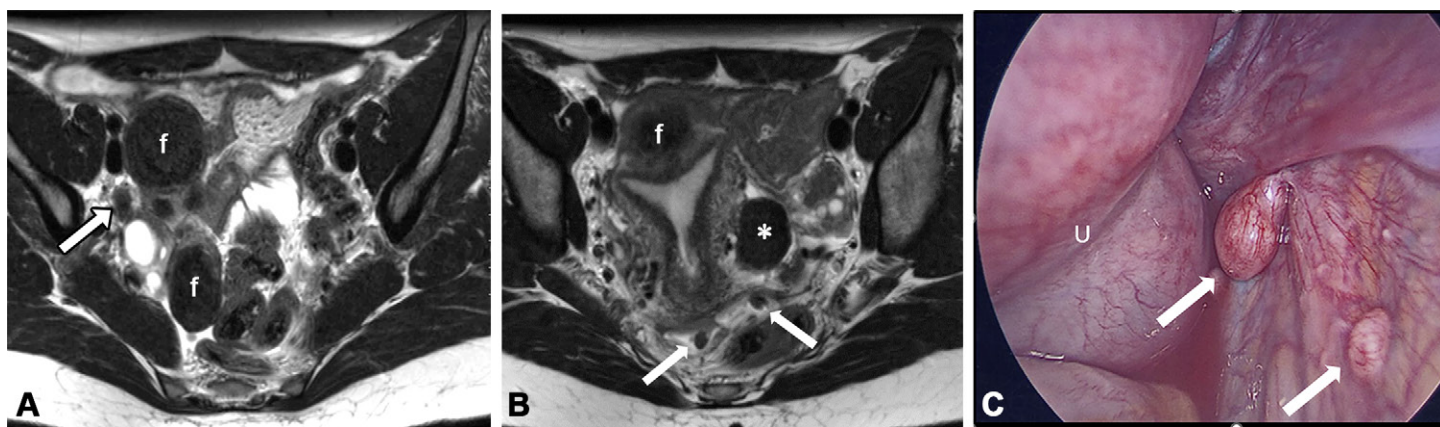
Diffuse peritoneal leiomyomatosis found at workup for infertility in a 40-year-old woman with no prior history of uterine procedures. (A) Axial T2W MR image partially shows multiple subserosal leiomyomas (*f*) and a small hypointense nodule (arrow) along the right pelvic sidewall. (B) Axial T2W MR image at a slightly more inferior level shows a leiomyoma of the left broad ligament (*), additional peritoneal nodules (arrows) in the cul-de-sac, and subserosal leiomyomas (*f*). (C) Laparoscopic image of the right pelvic sidewall shows a fibroid uterus (*U*) medially and multiple nodules (arrows) along the right pelvic sidewall, one of which is seen in A.
